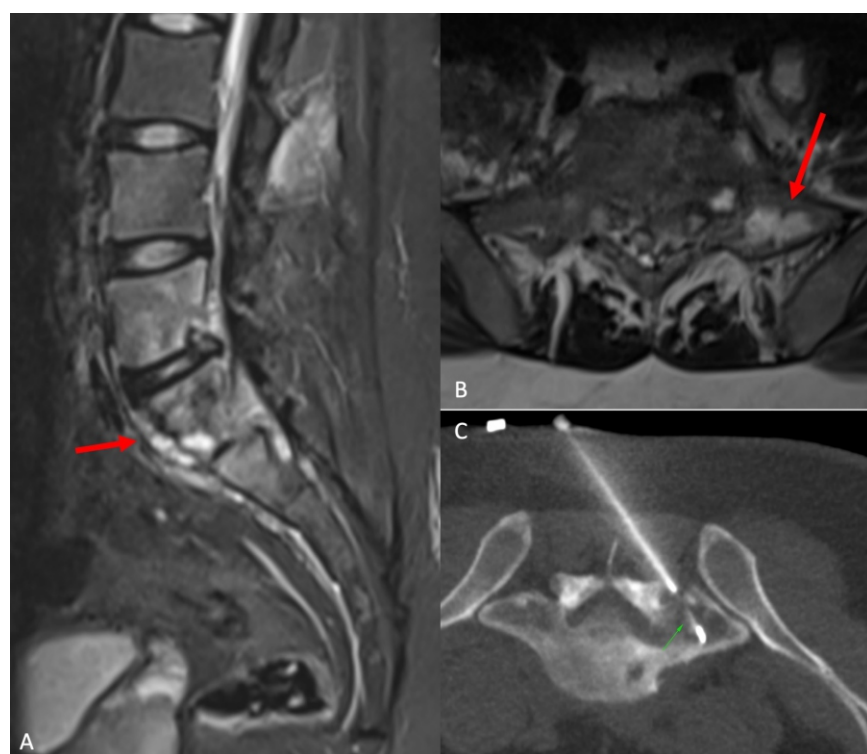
(A-C): *Coccidioides immitis*. 26-years old man from India working in the US had come for vacation and had fever and back pain. The STIR sagittal MRI (A) shows infectious spondylitis (arrow), typical for tuberculosis at L5/S1 with osteolysis in the left sacral ala (arrow) on the STIR axial MRI (B). A CT guided biopsy of the sacral alar component (arrow) was performed. After one week, the microbiologist called asking whether the patient was from one of the Southern US states because the only way to justify the diagnosis of *Coccidioides immitis*, is if the patient is residing in those specific areas of the US. On asking, the patient confirmed studying for 2 years in one of those states, where *C.immitis* is endemic.
